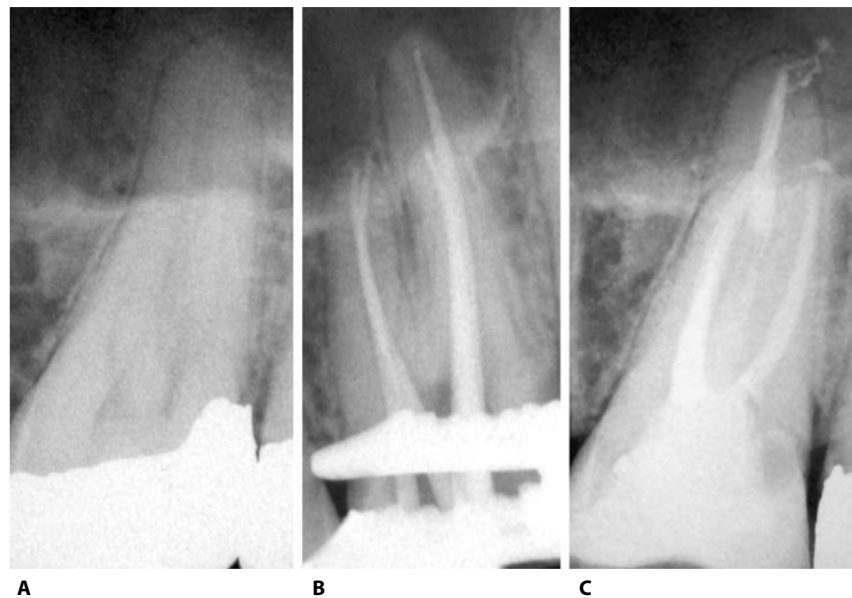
A. Pre-operative radiograph. B. Working length with plastic verifier. C. Post-operative radiograph after restorative reconstruction with a fiber post in the palatal root.
